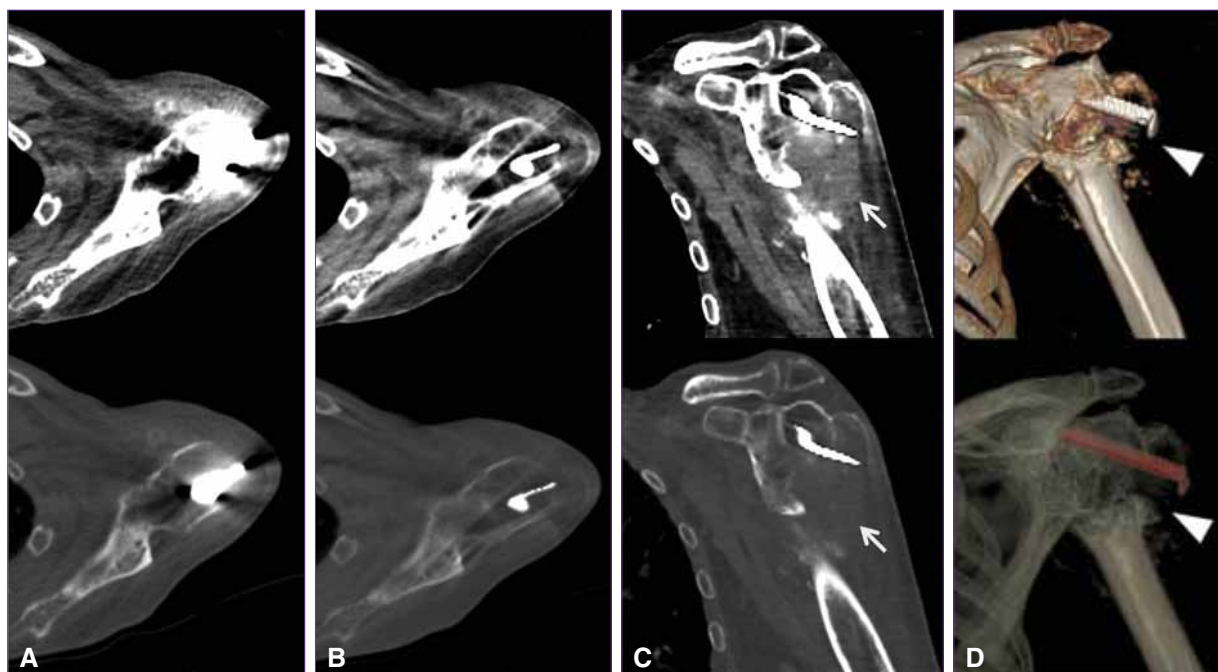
Eighty-seven year-old male with left proximal humeral fracture after undergoing surgery. Dual-energy CT scan. A. Polychromatic transverse images showing periprosthetic artifacts that hamper seriously the evaluation of the shoulder. B and C. Transverse and oblique coronal virtual monochromatic images with MARS which reduce artifacts significantly and evidence the fracture with epiphyseal detachment and signs of bone resorption and granulation/fibrosis tissues associated. D. Tridimensional images generated by the virtual monochromatic data that show clearly the fracture and the position of the prosthesis.
